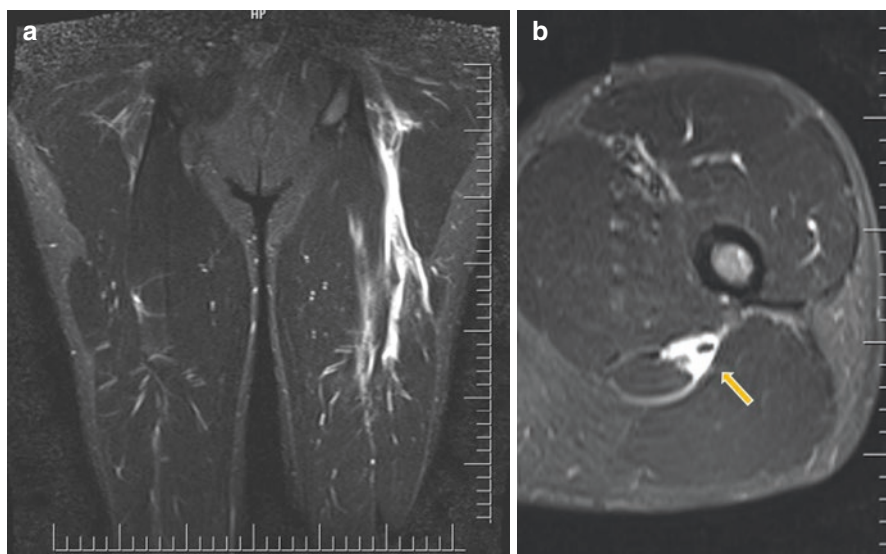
MR image in a 23-year-old professional male football player with a sudden onset of posterior hip pain. T2-weighted coronal image shows longwise extending edema and hemorrhage (a); axial image (b) shows complete tear of the hamstring tendon (arrow) proximally close to its origin at ischial tuberosity
